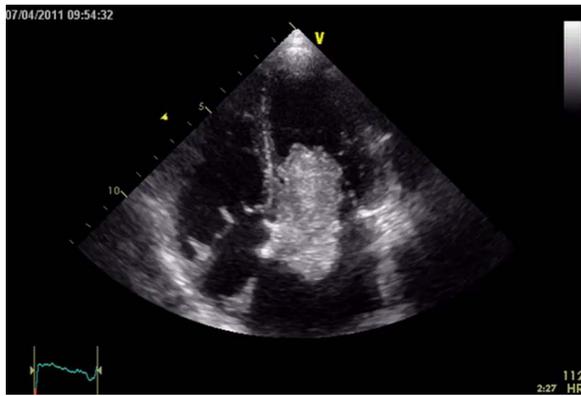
Large left atrial myxoma on transthoracic echocardiography (four chamber view, arrowed).
